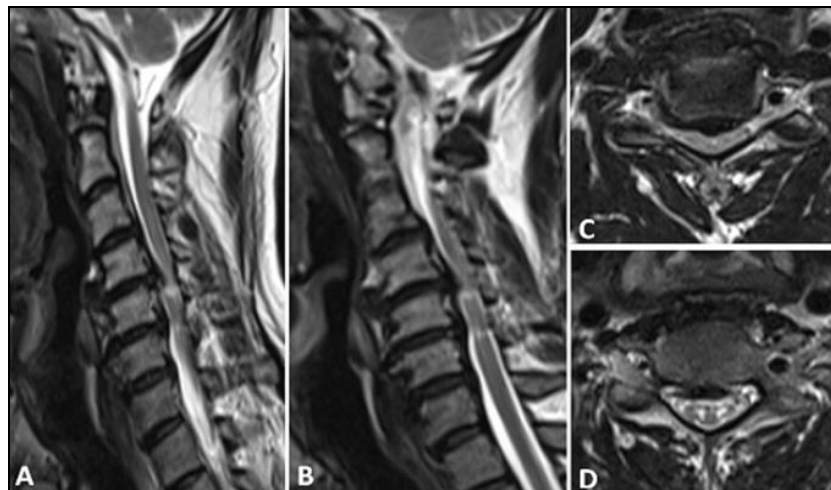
Degenerative Myelopathy: T2W sagittal (A,B) and axial (C,D) MRI Cervical spine images show posterior disc-osteophyte complexes at C4-5 and C5-6 levels causing thecal sac compression and moderate spinal canal stenosis leading to focal compressive cord myelopathy with syrinx formation at C4-5 (C) and C5-6 (D) levels.
